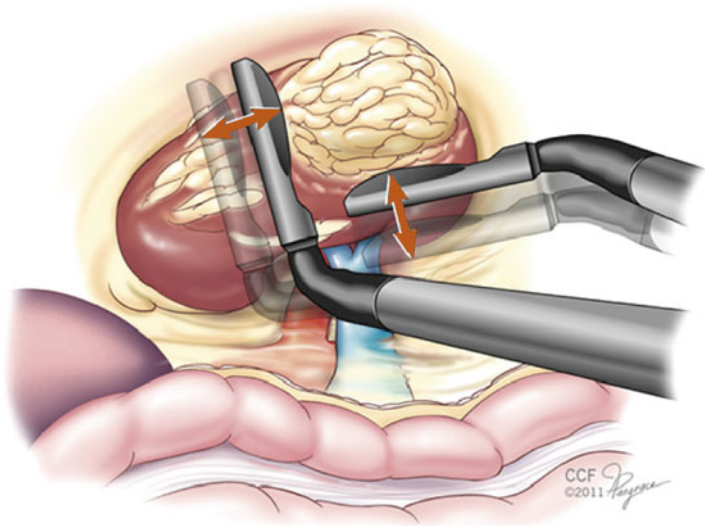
Laparoscopic ultrasound during robotic partial nephrectomy
